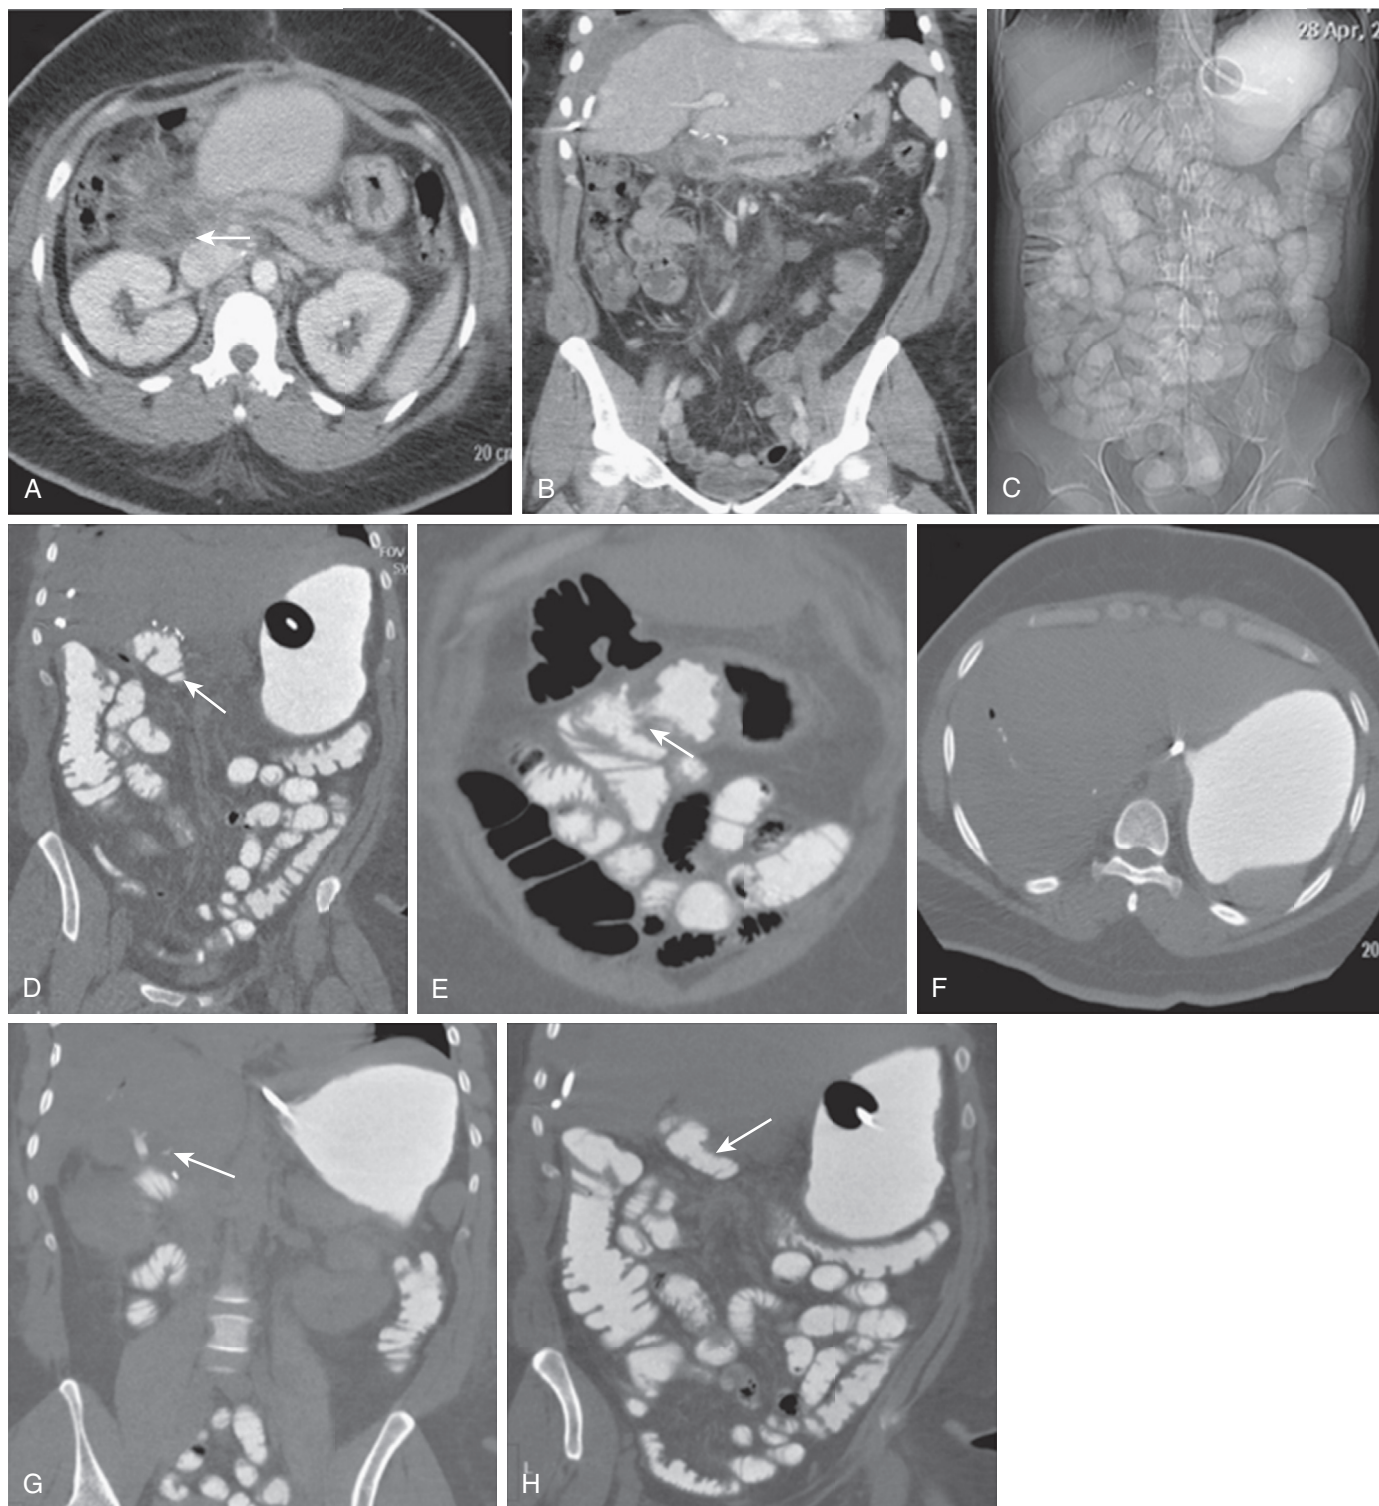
CT Whipplegram. A. Axial CT of a patient after recent Whipple procedure. This was done for a neuroendocrine tumor with persistent vomiting and nonresolving fluid collection in the perihepatic space that was referred for CTE to exclude distal SBO and leak at the level of a pancreaticojejunostomy. Note reactive inflammatory changes to the right of the dilated pancreatic duct (*arrow*). B. Coronal image shows fluid collection and drainage catheter in the right perihepatic space. C. Scanogram showing uniform distention of the SB with antireflux balloon of enteroclysis catheter immediately distal to the gastroesophageal junction. D. Coronal CTE image shows normal caliber of biliopancreatic limb (*arrow*). E. Coronal image shows a patent pyloroduodenal anastomosis (*arrow*) without evidence of a leak. F. Axial image shows small amount of pneumobilia and contrast in the intrahepatic tributary. G. Coronal image of CTE shows small amount of leak to the left of the hepaticojejunostomy (*arrow*). H. Coronal image of CTE shows no evidence of distal mechanical SBO. The *arrow* points to a well-delineated biliopancreatic limb.
